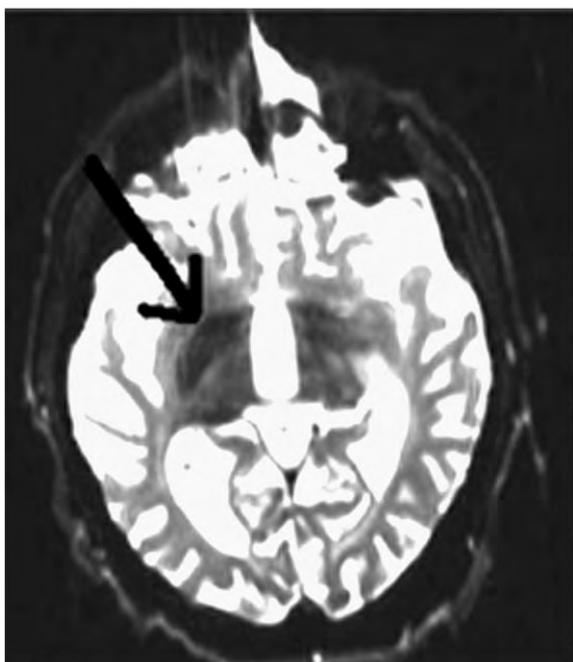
Kufor-Rakeb disease (KRD). T2*-weighted MRI demonstrating bilateral caudate and putamen hypointensities (arrow) suggestive of augmented iron deposition. From [77], with permission.
